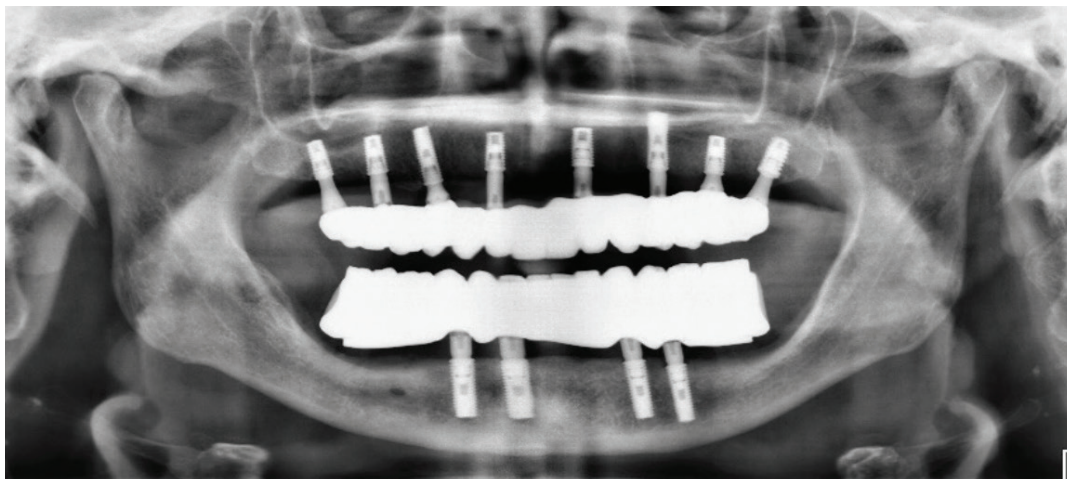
End of case panoramic radiograph.
